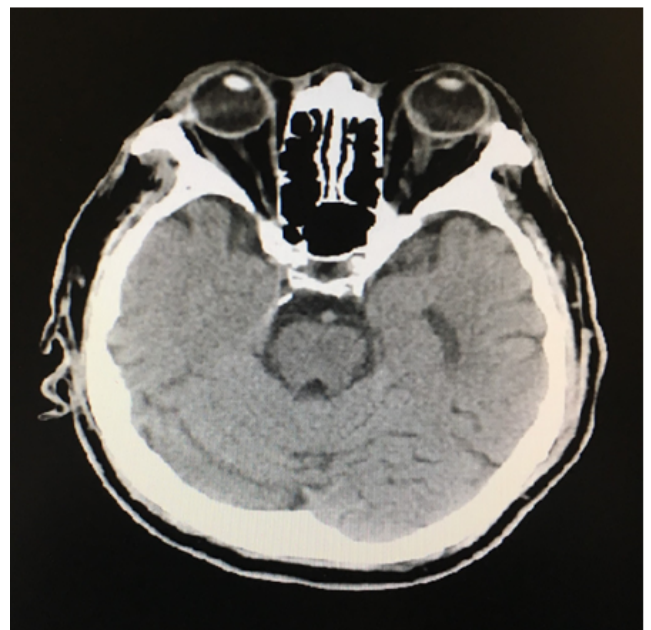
Cranial Computed Tomography.
